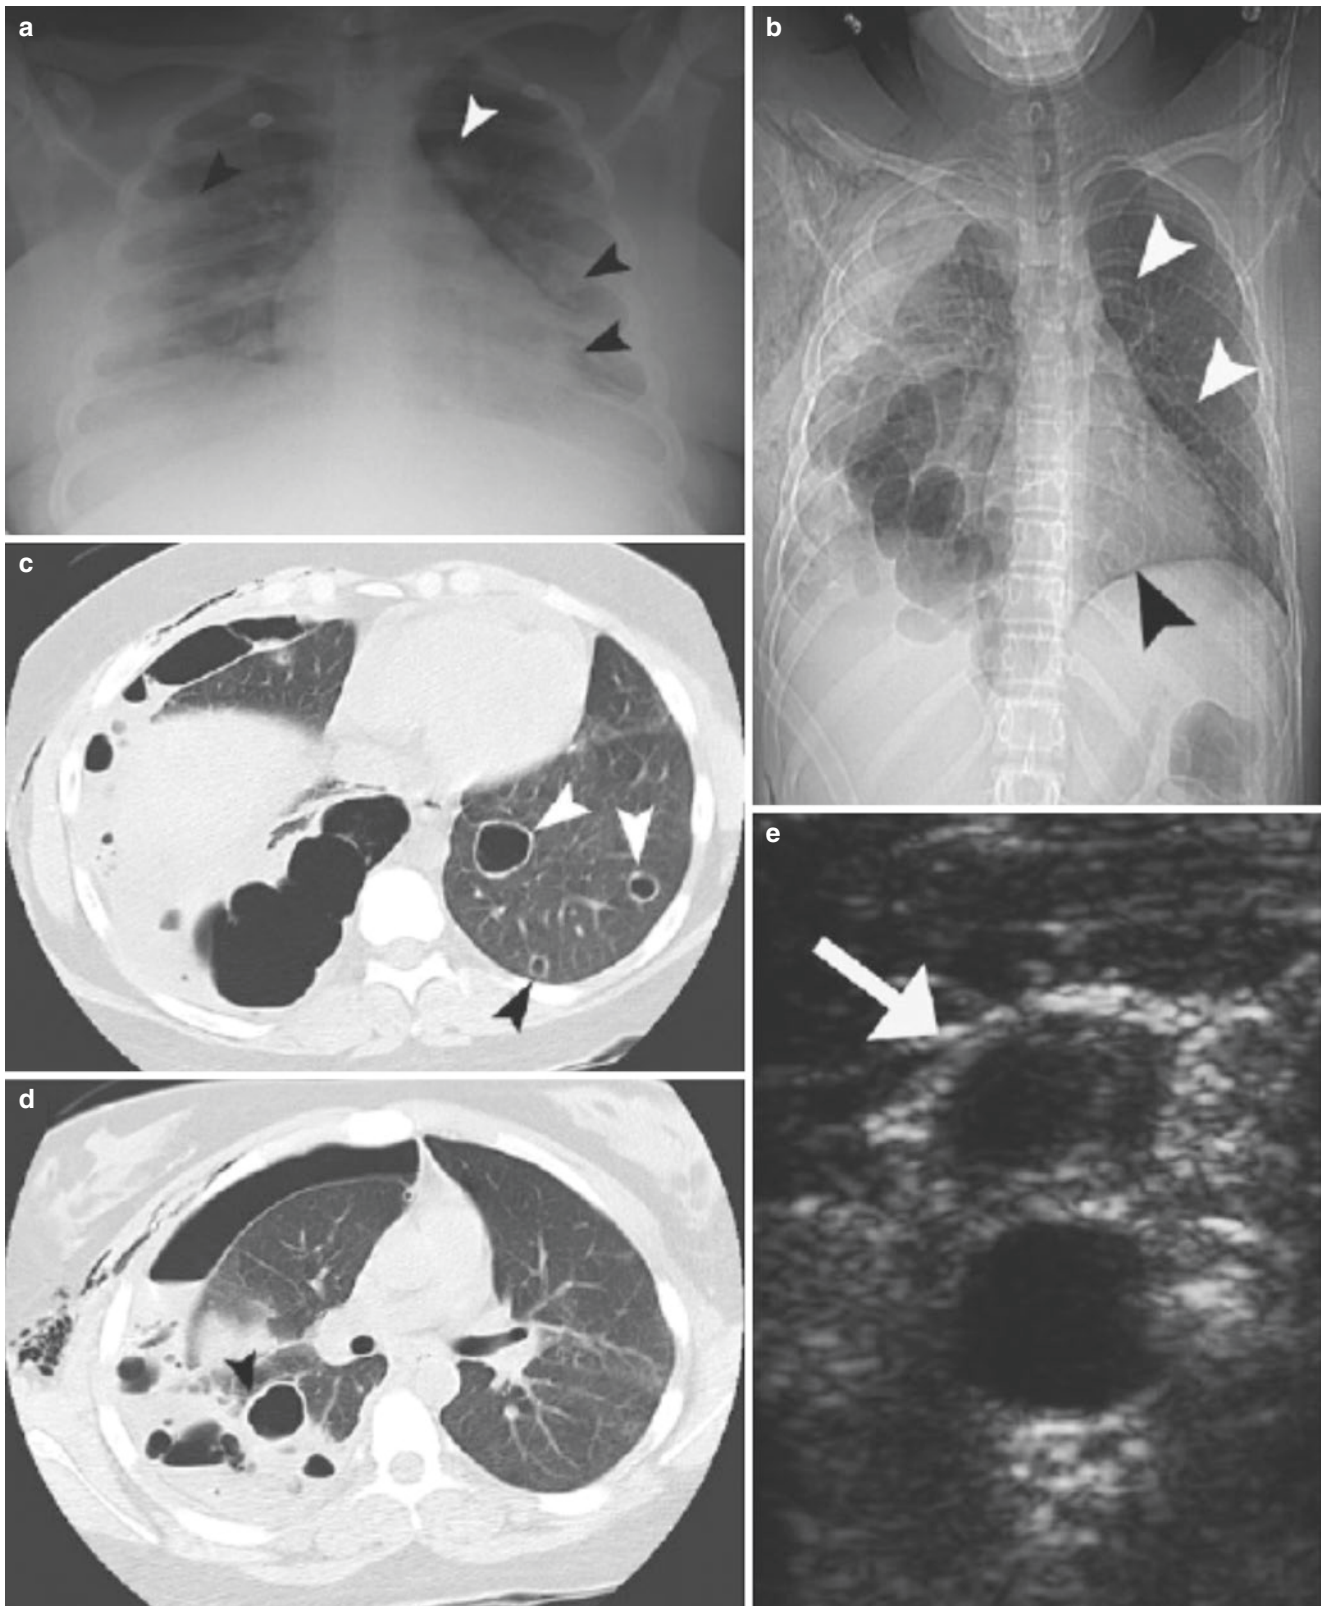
Septic emboli in a 16-year-old girl with recent history of sore throat and fever. Blood cultures were positive for *Fusobacterium necrophorum*. (a) Initial frontal chest radiograph shows ill-defined, rounded opacities (arrowheads) and right peripheral pleural-based opacity consistent with pleural fluid. (b) Scout image from CT obtained 6 days later shows thin-walled lucent cysts (arrowheads) on the left and multiple air-filled cavities on the right with a chest tube. (c) Axial lung
